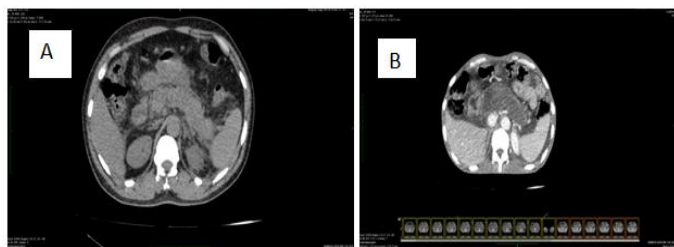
CT axial images show (A) Bulky pancreas with fuzzy margins and peri pancreatic fat stranding. (B) Contrast enhanced CT shows bulky and hypoattenuating (edematous) non enhancing pancreas.
